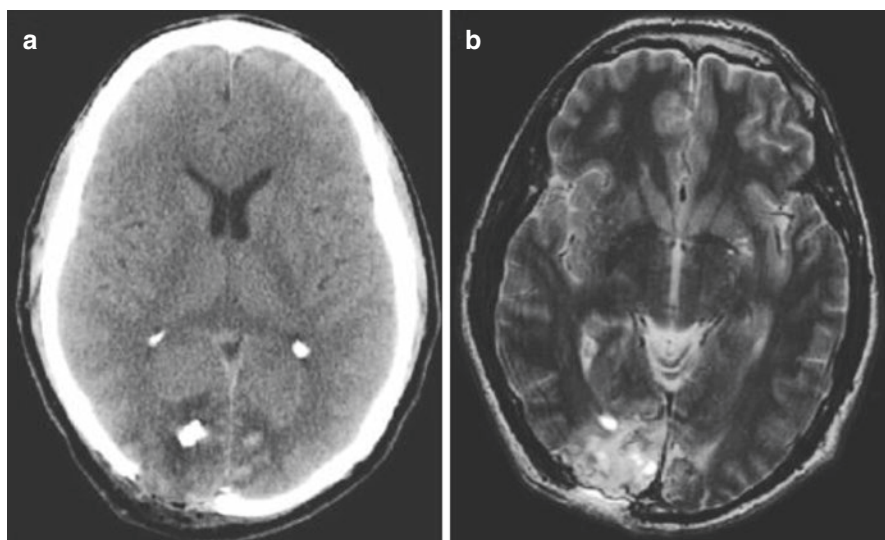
Tangential intracranial injury. (a) CT of tangential wound to right occipital region from a 7.62×39 mm round while wearing military helmet. The wound was emergently debrided at nearby field hospital. Note the in-driven bone fragments. (b) MRI of same patient revealing underlying contusion after CT confirmation of no residual metal fragments
